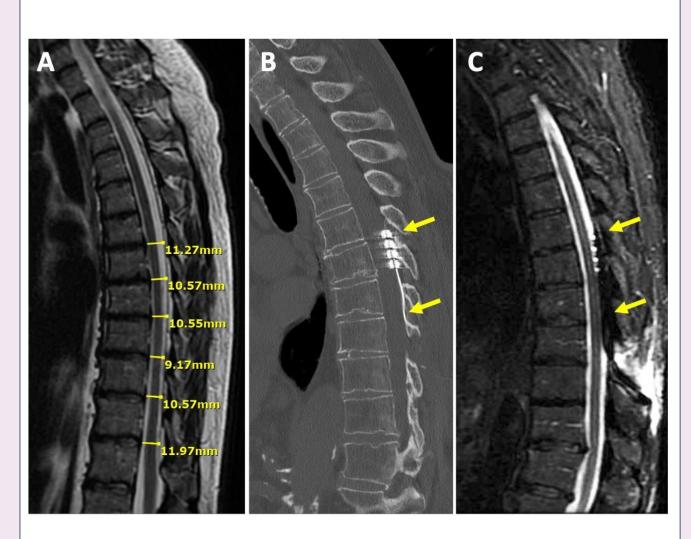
A. Sagittal T2WI MRI demonstrating measurement of thoracic canal diameter.
